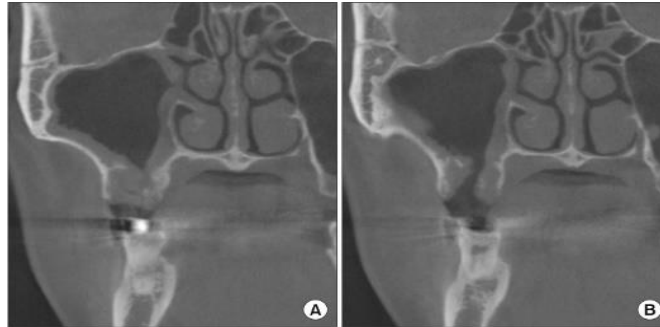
CT-Scan (a) connected tract (b) right maxillary sinus infection¹
